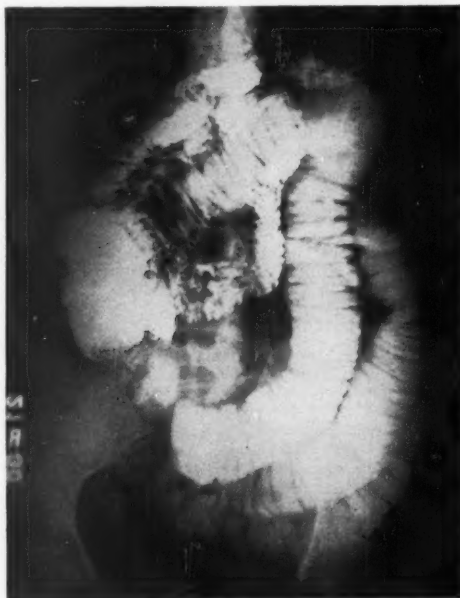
X-ray taken 1-11-49. Note the distension of the small bowel as brought out by the contrast medium.
